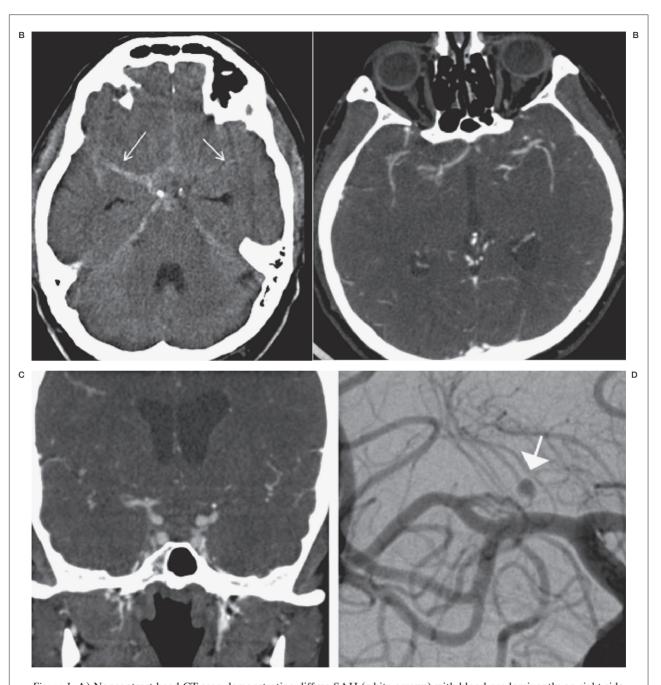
A) Noncontrast head CT scan demonstrating diffuse SAH (white arrows) with blood predominantly on right side. B,C) Axial and coronal CT angiogram did not reveal the aneurysm. D) Anteroposterior view of right internal carotid selective digital subtraction angiography demonstrating lenticulostriate fusiform aneurysm (thick white arrow). Exact vessel origin could not be determined despite 3D spin angiogram (not shown).
